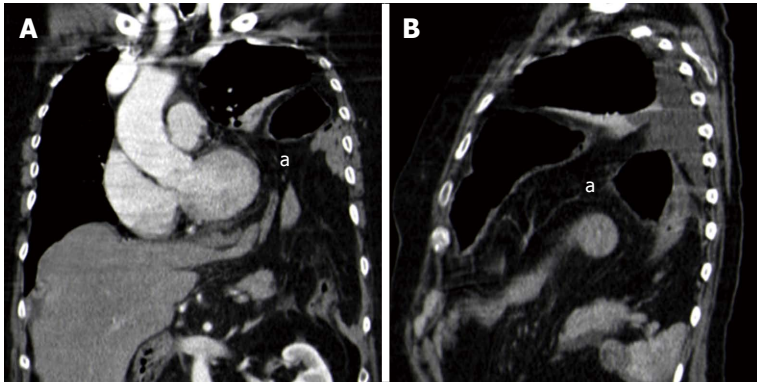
Computed tomography findings in blunt diaphragmatic lesions - intrathoracic viscera herniation. These 3 mm thick coronal (A) and sagittal (B) multiplanar reconstructions show intrathoracic herniation of abdominal organs and fat (a). This finding is often associated with diaphragm non-visualization or with large diaphragmatic defects.
